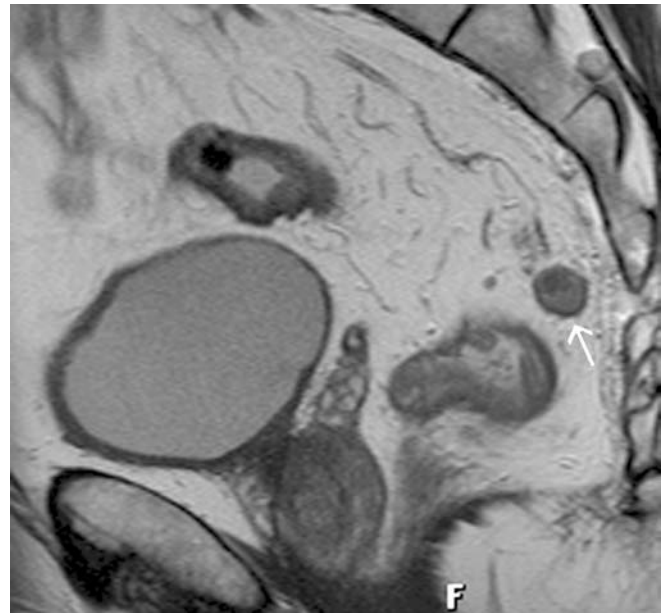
Sagittal T2-weighted FSE (TSE) sequence. The enlarged mesorectal lymph node (arrow) shows heterogeneous signal intensity indicating tumor invasion
